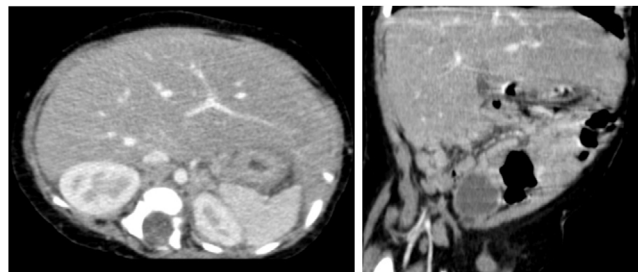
Computed tomography scan of the abdomen in the axial and coronal planes with contrast evinced hepatomegaly with a homogeneous pattern.
